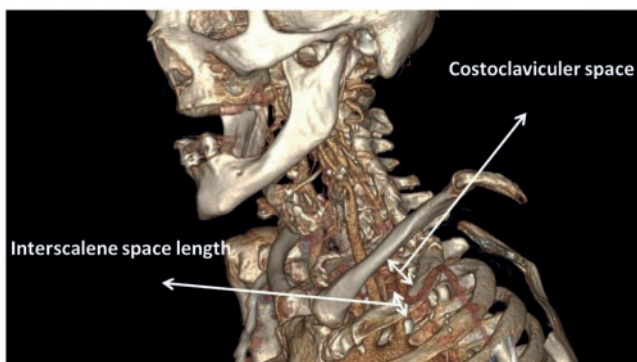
Computed tomography angiography showing the interscalene space length and costoclavicular space width.
